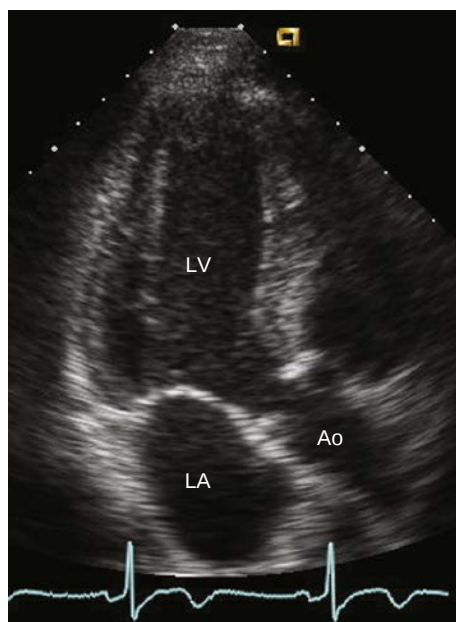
Apical long-axis view. This view is obtained by rotating an additional 60° counterclockwise to obtain an image similar to the parasternal long-axis view. Ao, Aortic.
